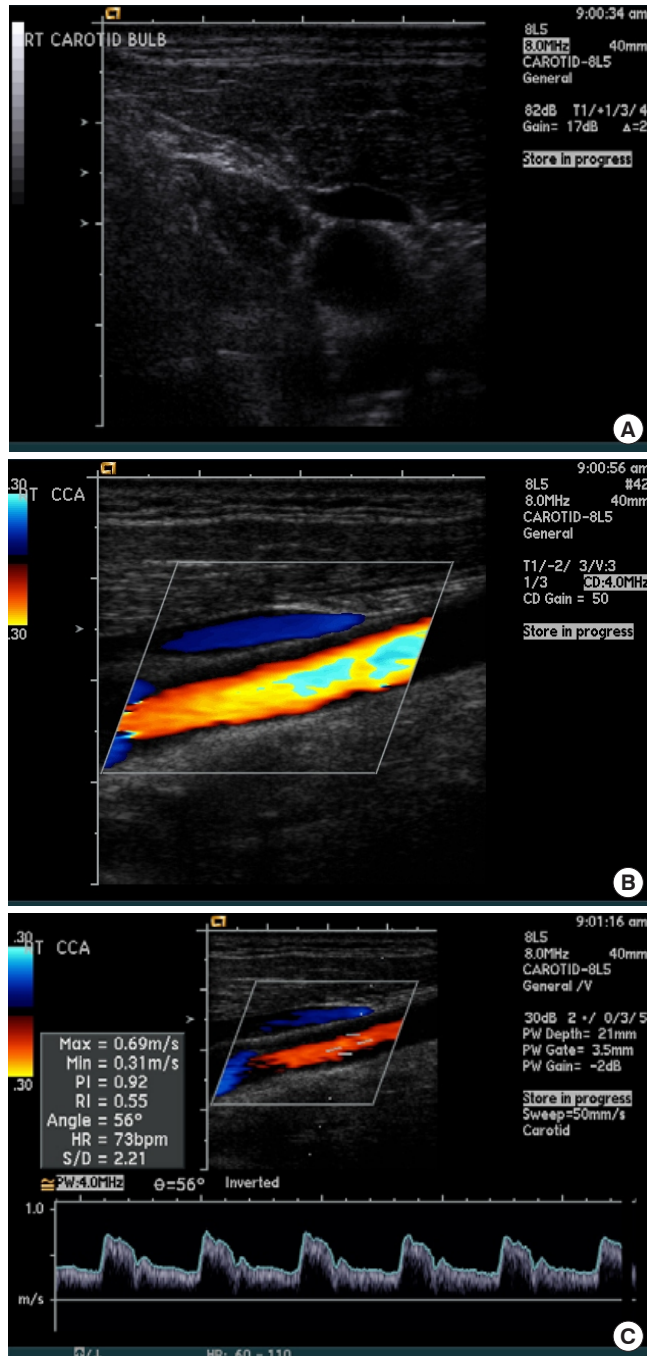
Preoperative duplex ultrasound measurements of the right carotid artery in a patient who developed an asymptomatic cerebral thromboembolic event after surgery. No atherosclerotic carotid artery disease, including mural plaque was present. (A) Axial. (B) Longitudinal. (C) Velocity.
